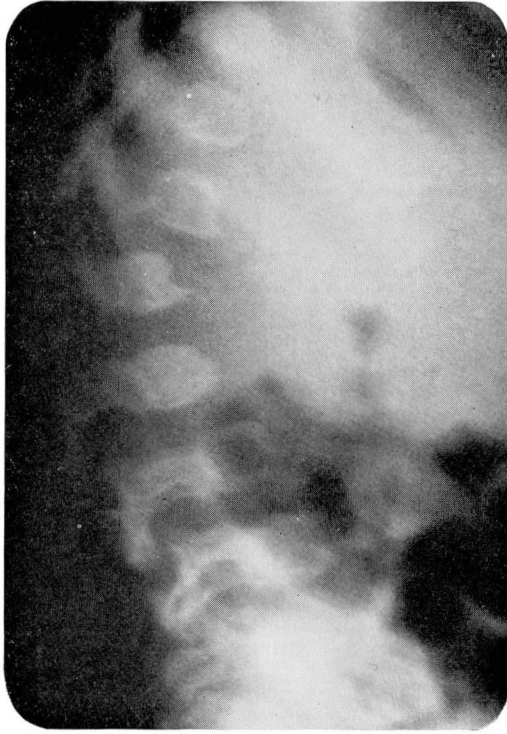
Roentgenogram, lateral view of the thoracolumbar vertebra. Note anterior hooklike projection on the second lumbar vertebral body.
